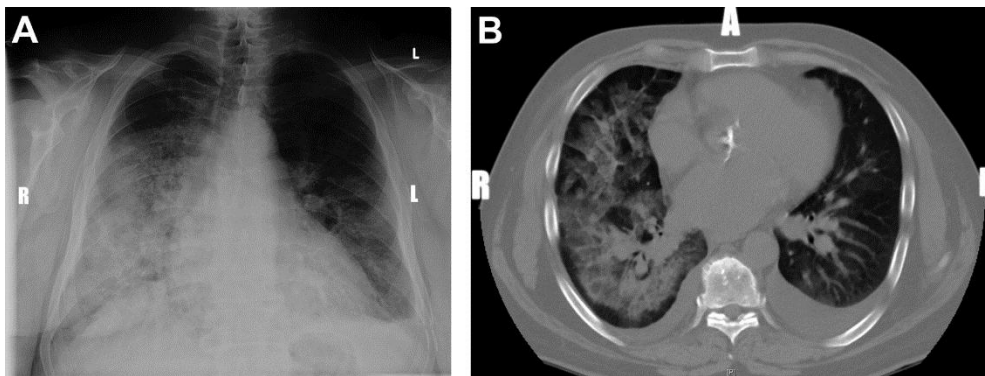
Chest X-ray (A) and CT image (B) demonstrate right sided pulmonary edema. Source: (Warraich et al., 2011)
